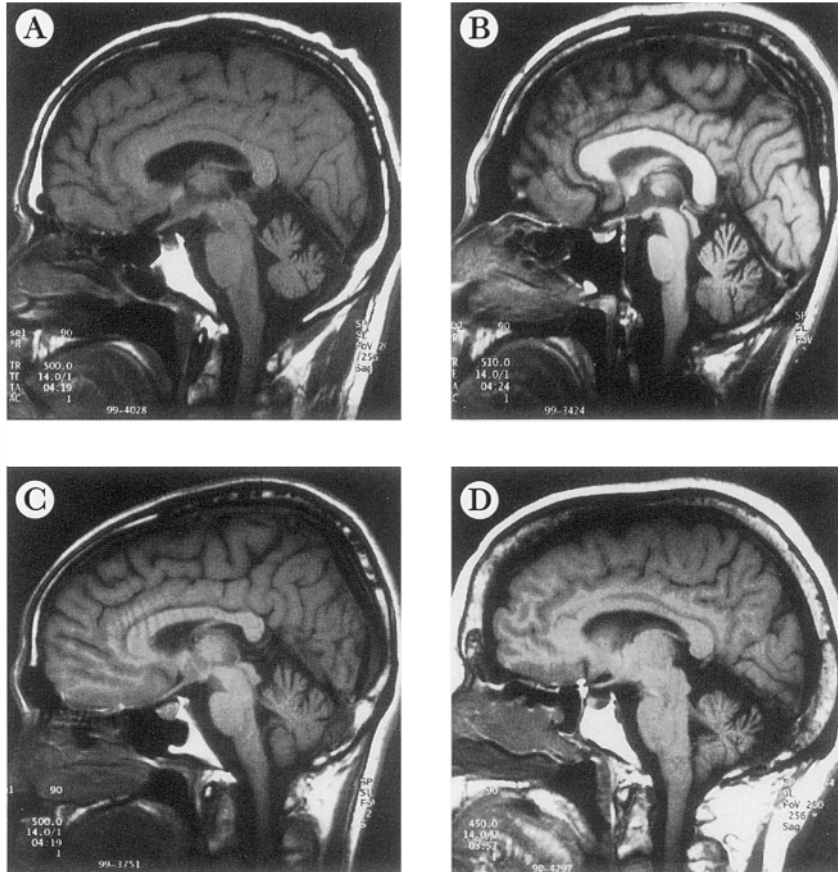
T1 weighted Magnetic Resonance Imaging of sagittal section from four spinocerebellar degeneration patients. A, Patient 1; B, Patient 2; C, Patient 3; D, Patient 4. In patient 1, 3 and 4, the atrophic changes were restricted to the cerebellum. Whereas, patient 2 showed atrophic changes of not only the cerebellum but also the brainstem.
